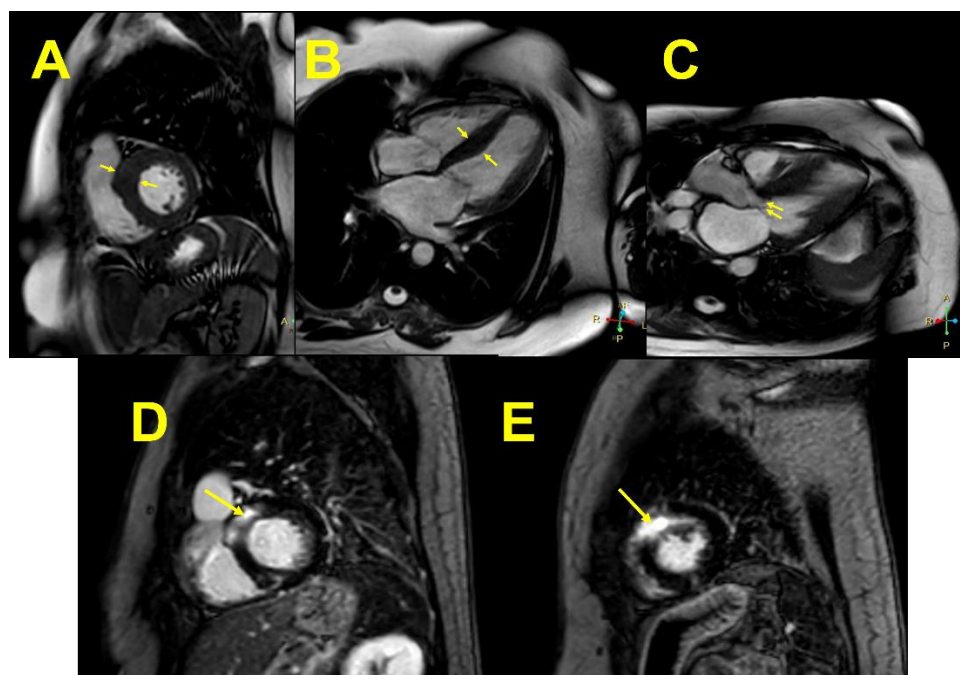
Cardiac magnetic resonance imaging. Steady-state free-precession sequence showing mid-short-axis (A) and apical 4-chamber (B) views, which show asymmetric septal hypertrophy (arrows); in addition, the 3-chamber view demonstrates a subaortic membrane (arrows) (C). The phase-sensitive inversion recovery sequence in basal and mid short-axis views demonstrates dense mid-wall late gadolinium enhancement, especially at the right ventricular insertion points (arrow), a typical pattern suggestive of hypertrophic cardiomyopathy (D, E).
